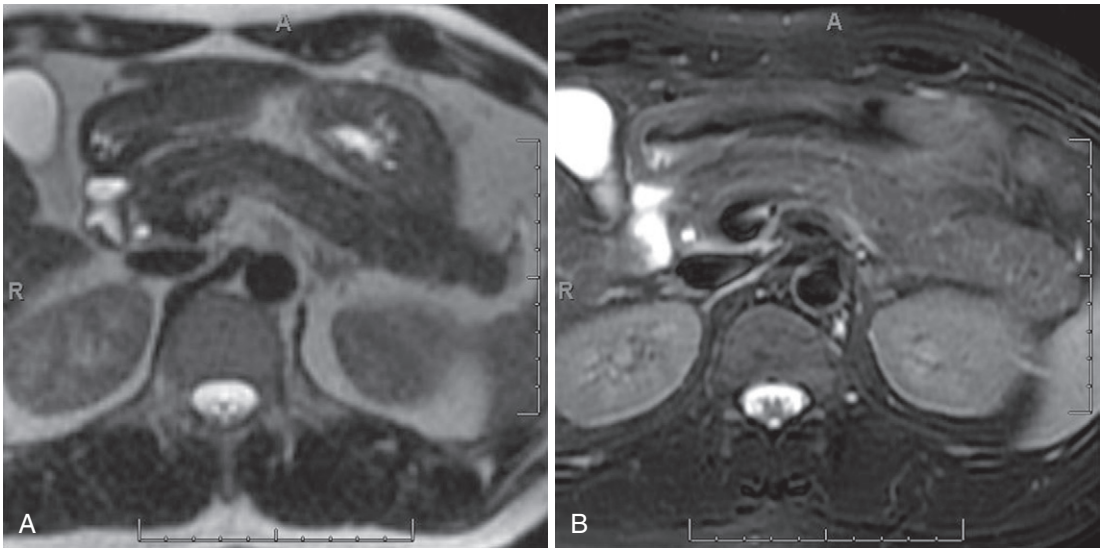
Normal appearance of the pancreas on T2-weighted images. Slightly increased T2-weighted signal intensity of the pancreas when compared with muscle (A), which is brought out after the addition of fat-suppression (B).
